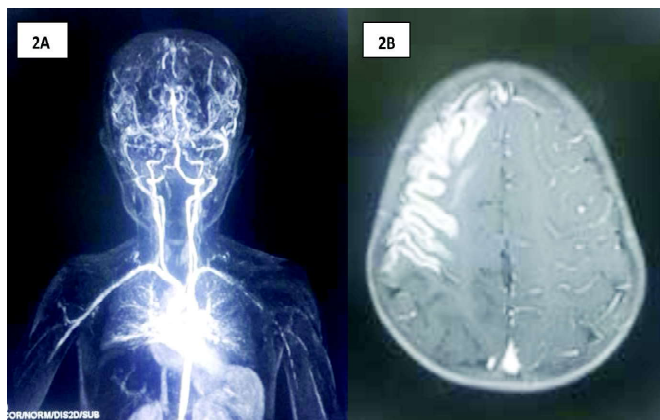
MR Angiography showing features of occlusion of bilateral ICA (L>R) circulation distal to their clinoid segments with multiple collateral vessels and underlying chronic ischaemic insults. Features are s/o Moya Moya disease. Figure (2B) MRI-Brain post-contrast study axial section showing intense gyral enhancement noted along right fronto-temporo-parietal lobar convexity
